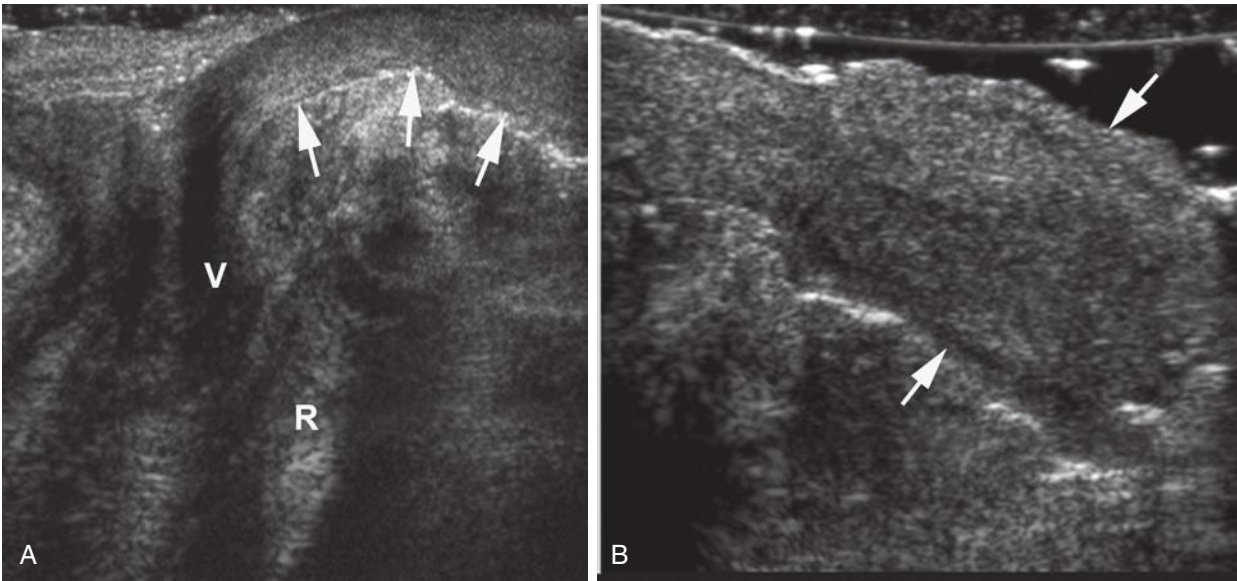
Fibroepithelial polyp in a 17-year-old girl with a mass protruding from the vagina. A and B, Sagittal transperineal ultrasound images depict a solid mass (*arrows*) extending through the vaginal lumen (V). R, rectum.
